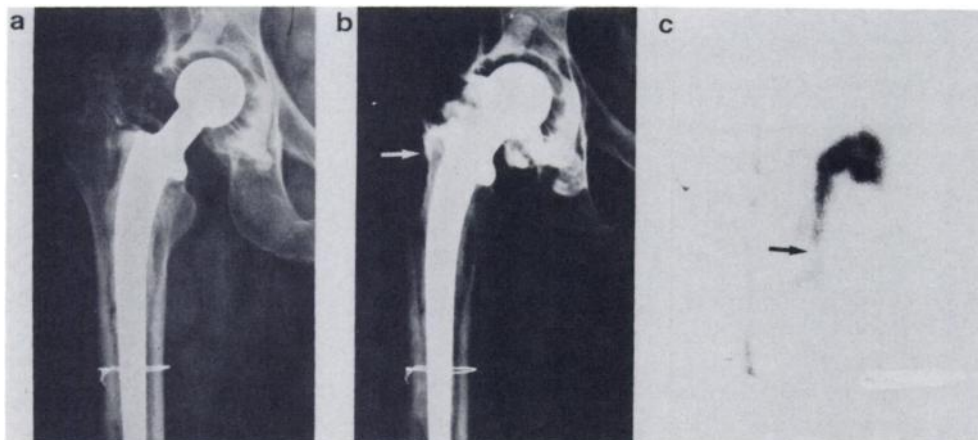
Positive XA and RA. (a) Plain film. (b) XA shows contrast only around the proximal aspect of FC (arrow). (c) RA: arrow points to activity extending all down shaft of FC. (Tc-99m marker along lateral aspect of thigh).
